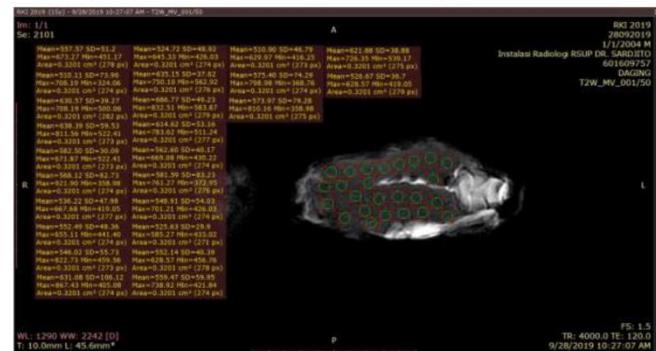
Twenty-five region of interests (RoI) were placed in muscle area and the mean number were recorded to get the average muscle tissue signal intensity of this T2-weighted image. This procedure were repeated for bone and background noise area.
